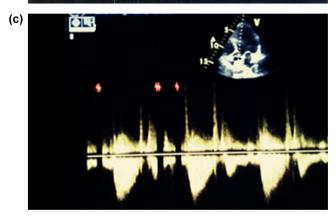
Doppler images of aortic flow: (a) group 1, (b) group 2A, and (c) group 2B.
